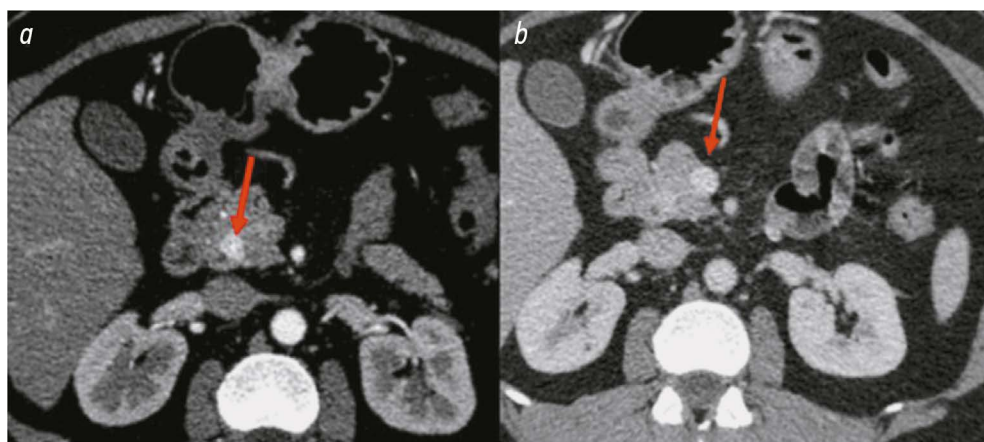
Abdominal computed tomography with intravenous contrast: *a*, a hypervascular lesion near the common bile duct during the arterial phase (10th second); *b*, venous phase image.
